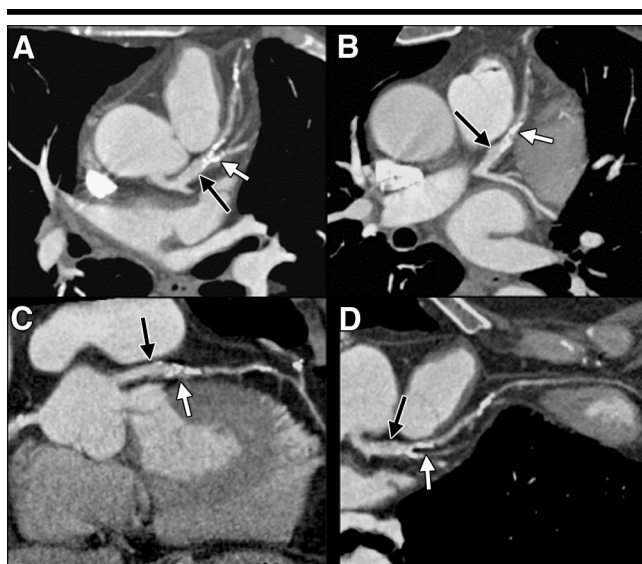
Positive coronary artery remodeling at four-detector row CT. *A*, *B*, Oblique transverse thin maximum intensity projections and, *C*, *D*, craniocaudal and, *D*, transverse curved multiplanar reconstructions demonstrate ectasia (black arrows) of the proximal LAD coronary artery, with irregularity of arterial wall due to early atherosclerotic plaque formation. The segment is followed by a densely calcified segment (white arrows) with luminal narrowing.
